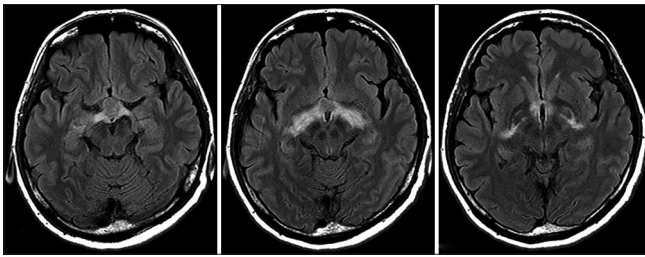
Preoperative axial fluid-attenuated inversion recovery (FLAIR) on MRI shows perifocal vasogenic edema reaching up to the mesencephalon bilaterally and to the internal capsule
